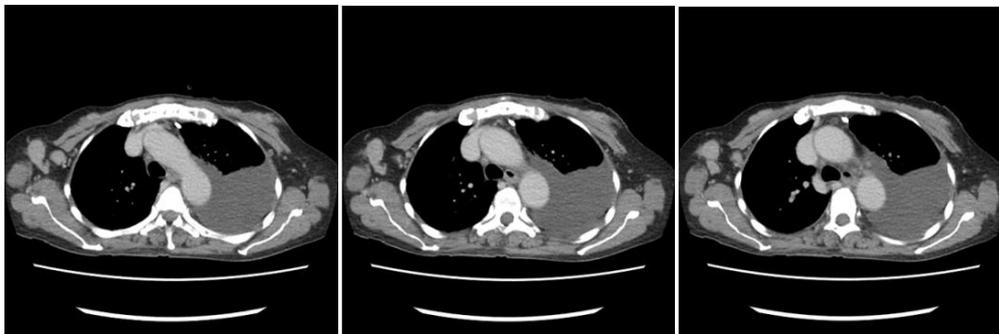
Chest contrast-CT scan demonstrated the central catheter migrating into the anterior mediastinum with left massive pleural effusion.
